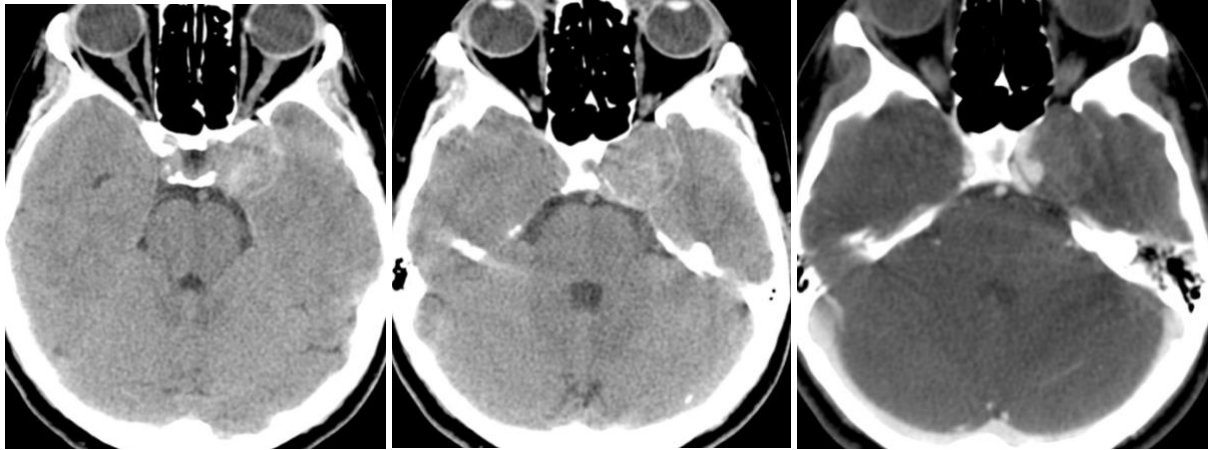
Pre-treatment CT scan showing no signs of SAH and partially thrombosed ICA aneurysm
